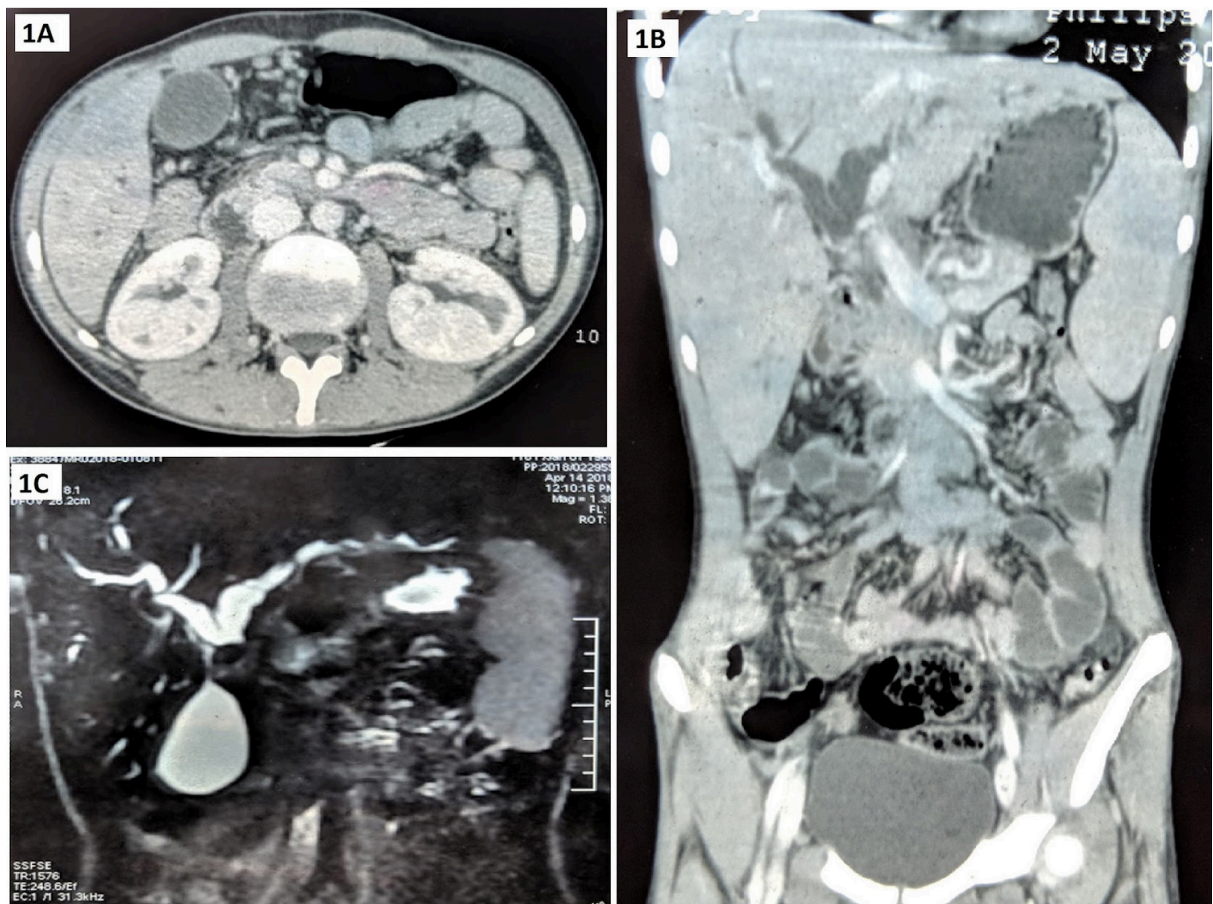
Contrast-enhanced abdominal computed tomography scan showing dilation of the biliary tree and an ill-defined mass, approximately 14.5 mm in diameter in common hepatic duct with heterogenous post contrast dilatation of rest of CHD and bilobar intrahepatic biliary radicle dilatation. (A,B) MRCP showing a filling defect in the common hepatic duct (C).
